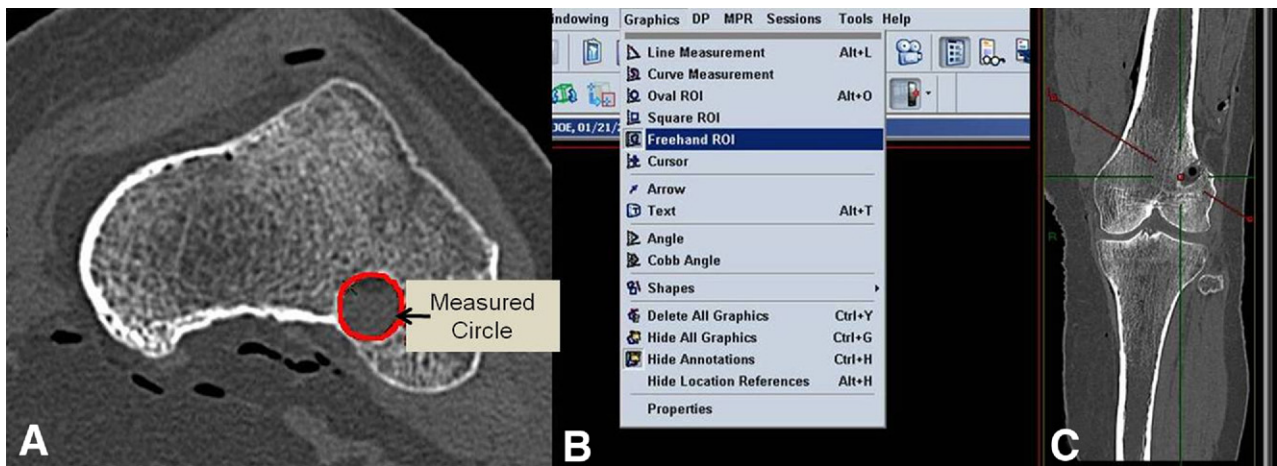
CT images of Carestream PACS system used to measure femoral tunnel. (A) Measurement of intra-articular aperture showing area obtained. (B) Toolbar with freehand region of interest (ROI) chosen for measurement. (C) The red line depicts the angle at which the tunnel length was obtained and volume was derived.
